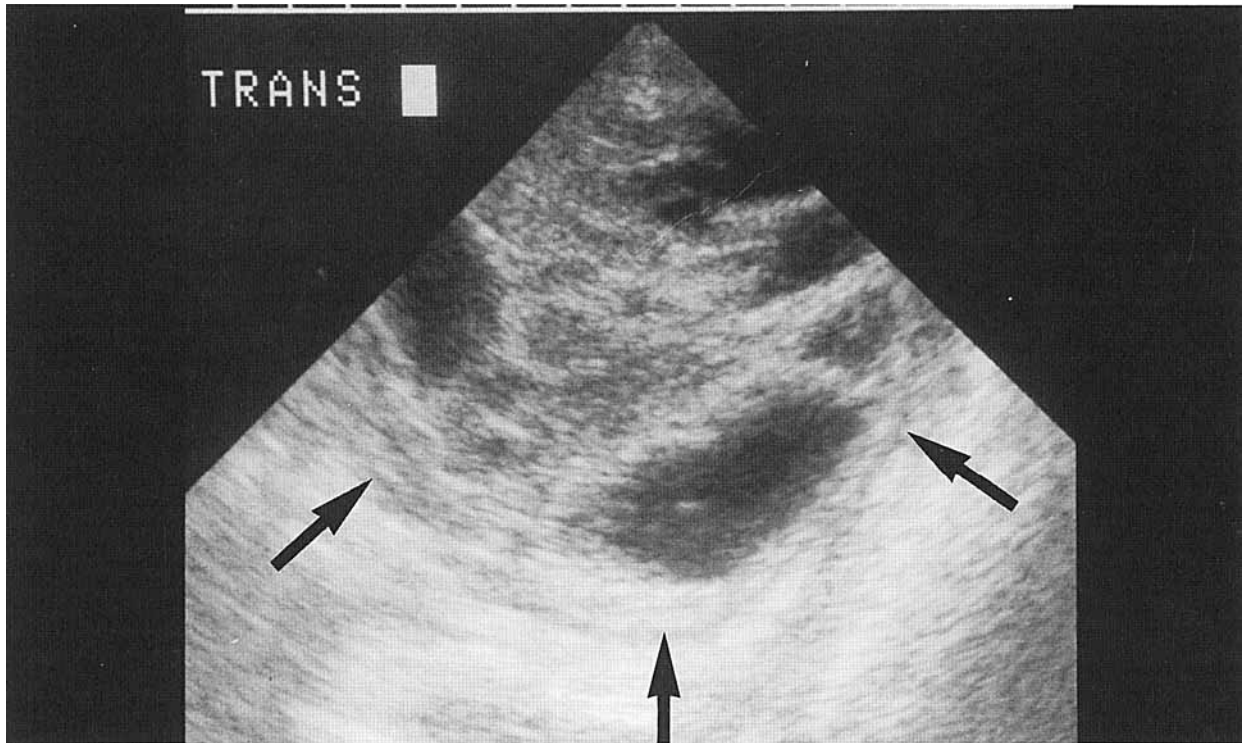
Postnatal transverse sonogram through the left upper quadrant. A complex cystic and solid mass (arrows) similar to the prenatal appearance is seen.
